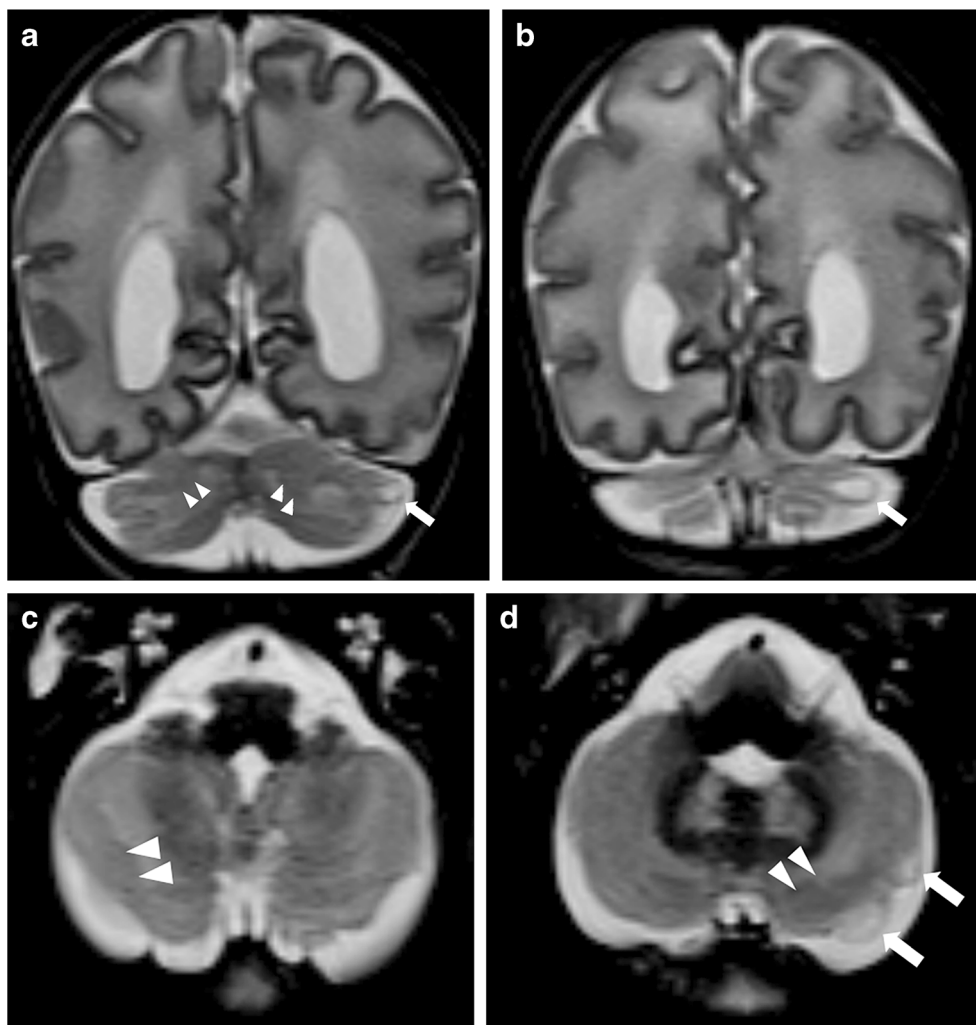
Brain MRI in a 27-day-old girl with congenital cytomegalovirus infection. a-d T2-weighted image (TR/TE 8,000/188 ms) in the coronal (a, b) and axial (c, d) planes demonstrates mild cerebellar hypoplasia, abnormal orientation of the cerebellar folia with irregular thickened cerebellar cortex and irregular gray-white matter junction, suggesting bilateral cerebellar dysplasia (*arrowheads*). Peripheral juxtacortical cysts (*arrows*) are seen in the left cerebellar hemisphere, in the vicinity of the dysplastic tissue
